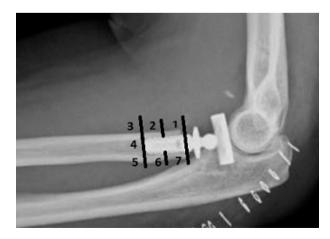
Zonal evaluation of radiographic changes on lateral x-ray using hip method developed by Gruen
